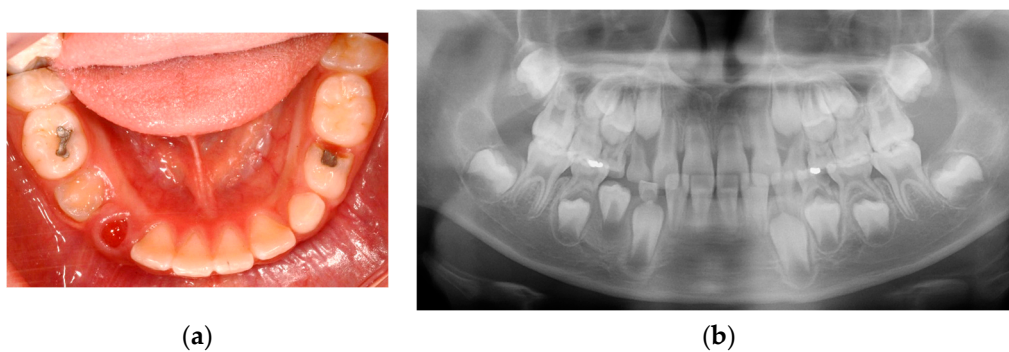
Two months after the marsupialization: (a) intraoral photo; (b) panoramic radiograph.
